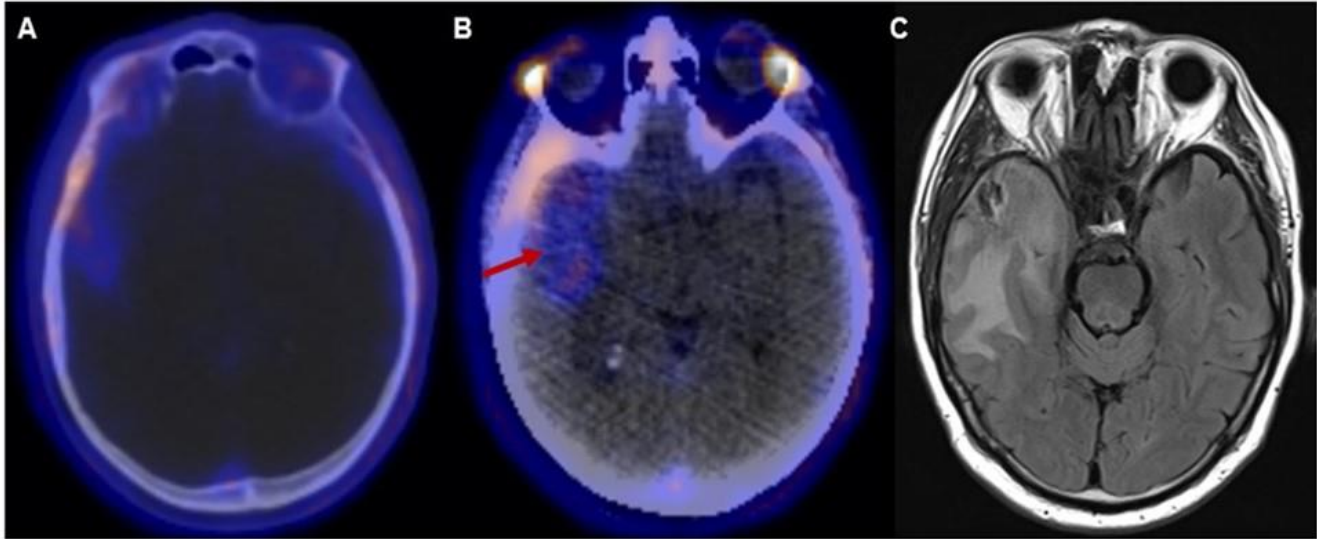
Headache investigation: A and B) axial fusion PET images show minimum concentration of PSMA in the skull lesion and appearance of temporoparietal hypodensity with SUVmax = 2.78; C) Brain MRI axial T2 shows increase of the right temporal lobe lesion size, with central necrosis and vasogenic cerebral edema return.
